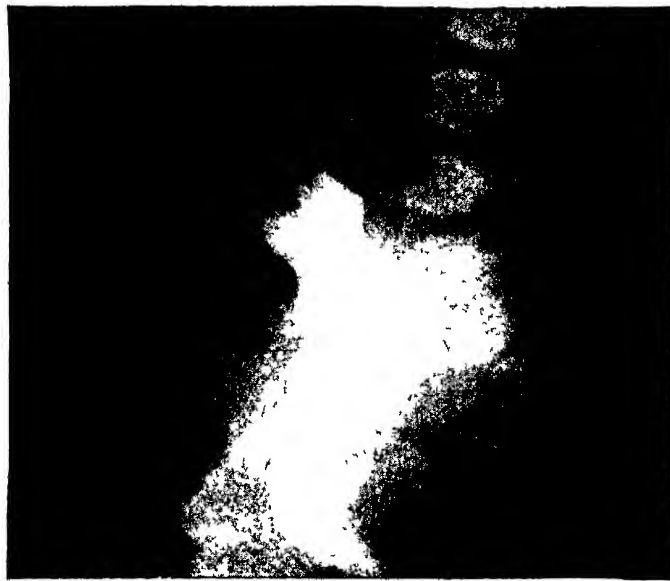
Case 18. Lateral roentgenogram of patient with cystic duplication of rectum. Barium in rectum shows it displaced forward by mass lying in hollow of sacrum. (Ladd and Gross: Surg., Gynec. & Obst.)
